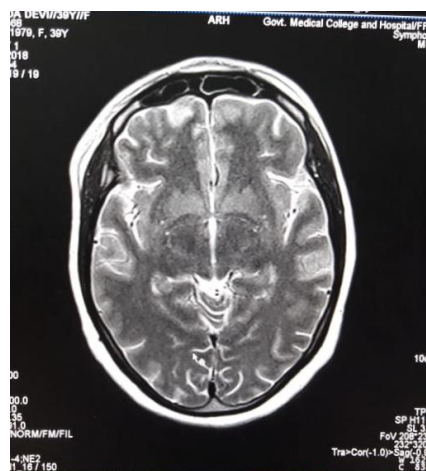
MRI Brain : left frontal lobe focal cerebritis.
